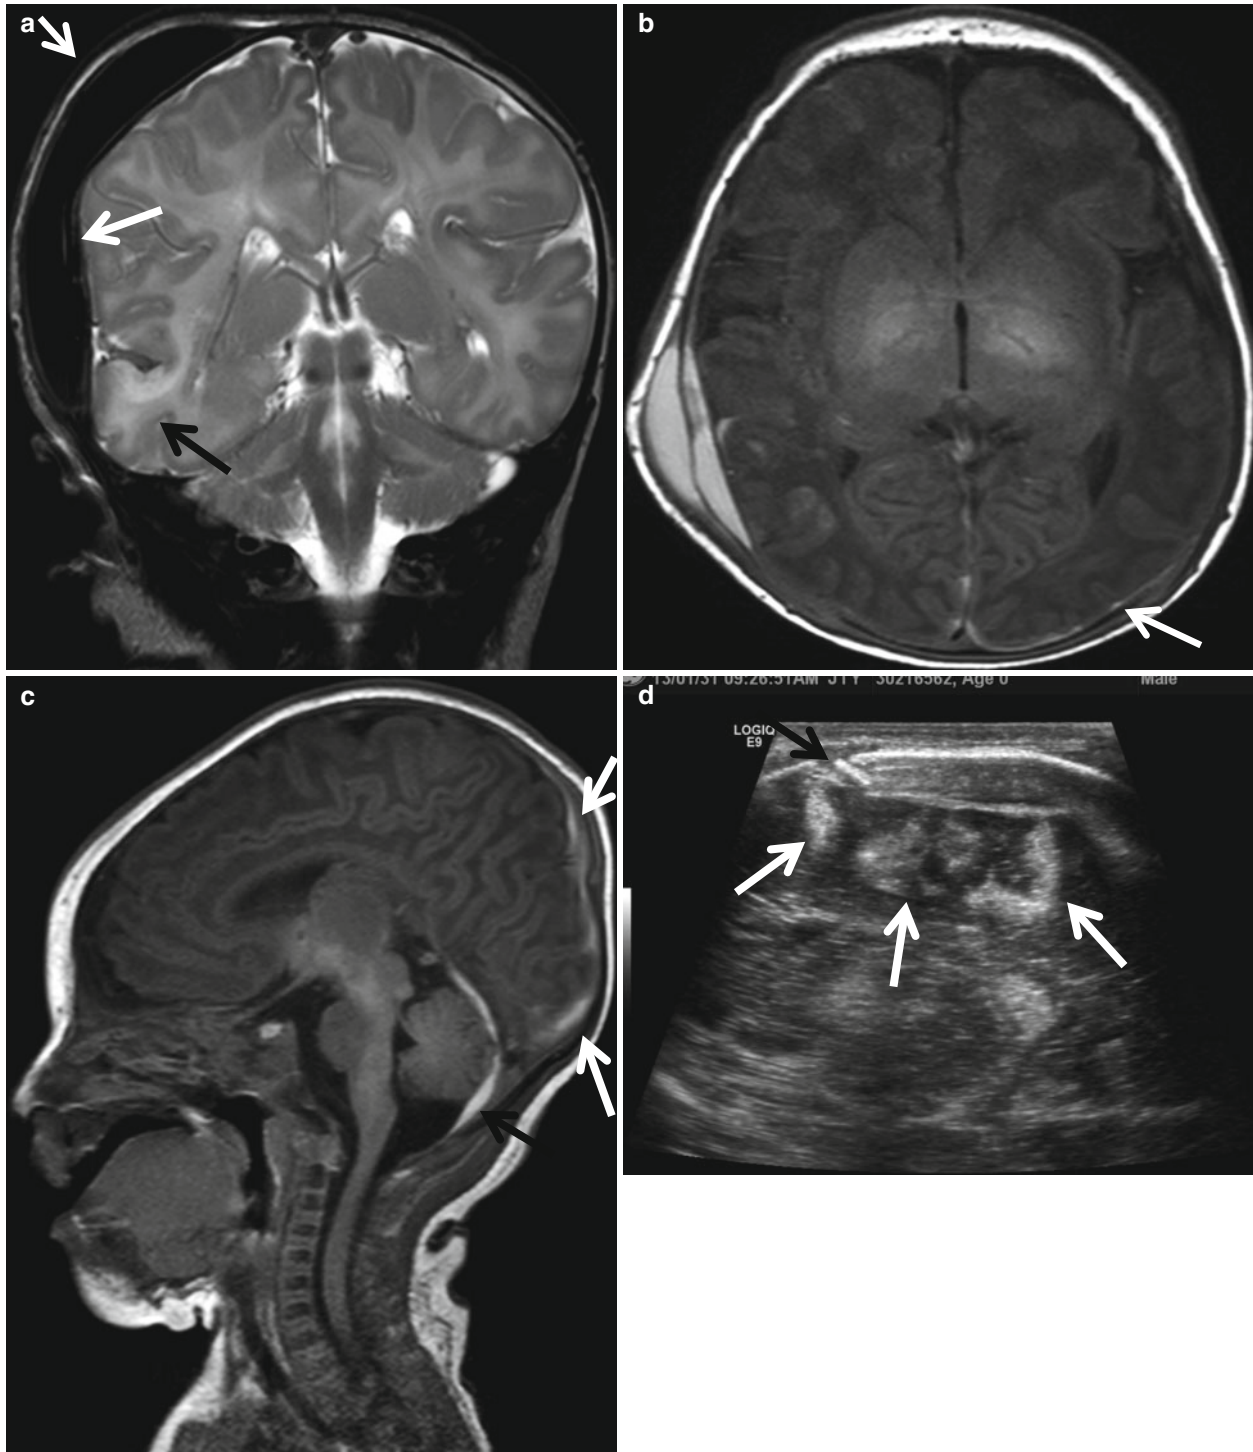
Birth trauma. (a) T2-weighted coronal image shows right temporo-occipital cephalhematoma as dark signal intensity (*white arrows*). Note the depressed contour of the skull suggesting fracture. There is contusion at the adjacent occipital lobe (*black arrow*). (b) The cephalhematoma is hyperintense on T1-weighted axial image suggesting subacute lesion. Multifocal SDH is also noted at the inside of the cephalhematoma as well as along the left occipital lobe (*arrow*). There
